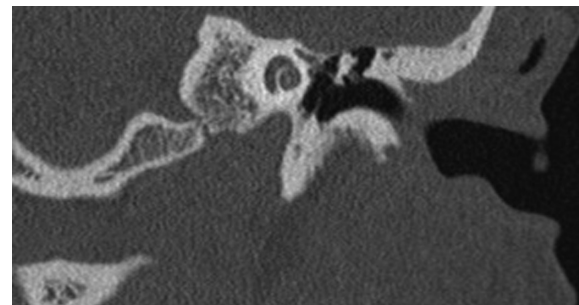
Temporal Bone Computed Tomography (TBCT) Coronal view, limited attic cholesteatoma. Note the tegmen dehiscence.
